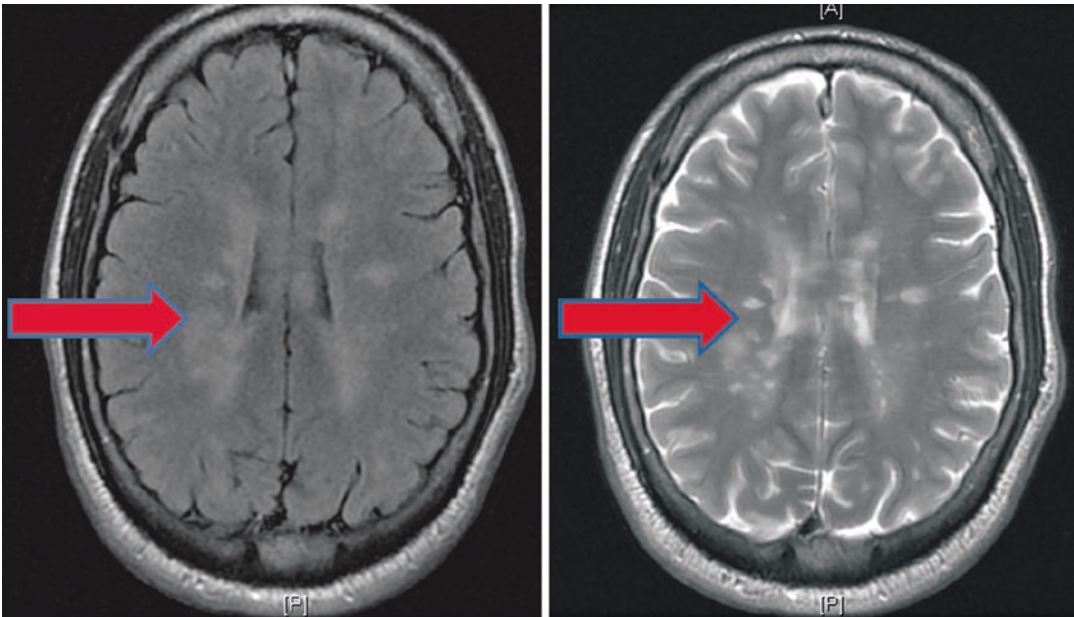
On MRI, white matter lesions are found throughout the left and right hemispheres and throughout the brain stem. These lesions resemble those seen in multiple sclerosis (MS). The lab evaluation for MS did not show
